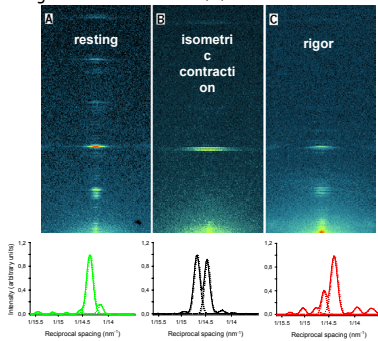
X-ray interference between the two bipolar arrays of myosin heads allows to measure with \AA -scale sensitivity the axial motion of myosin heads that drives the actin filaments toward the centre of the sarcomere. In the isometric contraction (T_0) the peak intensity ratio ($R = I_{M3}/I_{M1}$) is 0.8.
